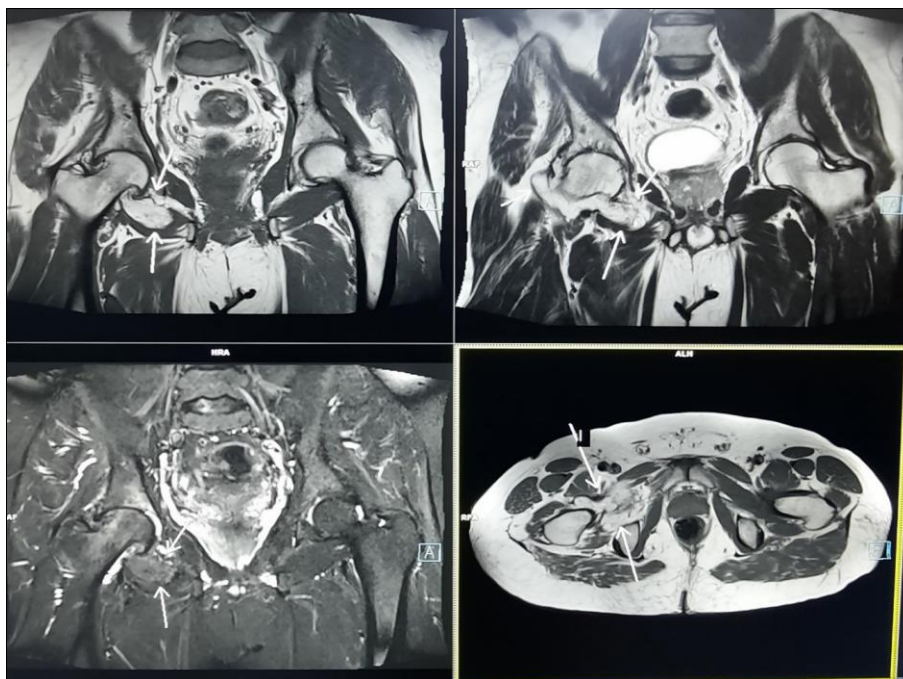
MRI depicting secondary arthritic changes of right hip joint associated with an intra-articular lobulated lesion where characteristic multiple frond-like villi projecting from the synovium with signal equal to fat were noted.
